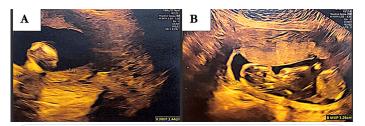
MCA dopplers had demonstrated a peak systolic velocity of 38.48 for fetus A, and 42.29 for fetus B, as shown in Figure *3A* and Figure *3B*. In this setting, it can be said that fetus A is the donor twin, fetus B is the recipient twin. This information is consistent with a possible diagnosis of TAPS. Patient recommendations included continued monitoring via ultrasound every two weeks, repeat fetal echocardiographs, continuation of low dose aspirin, and delivery of her twins at 34-37 weeks if the rest of the pregnancy proved uneventful.
